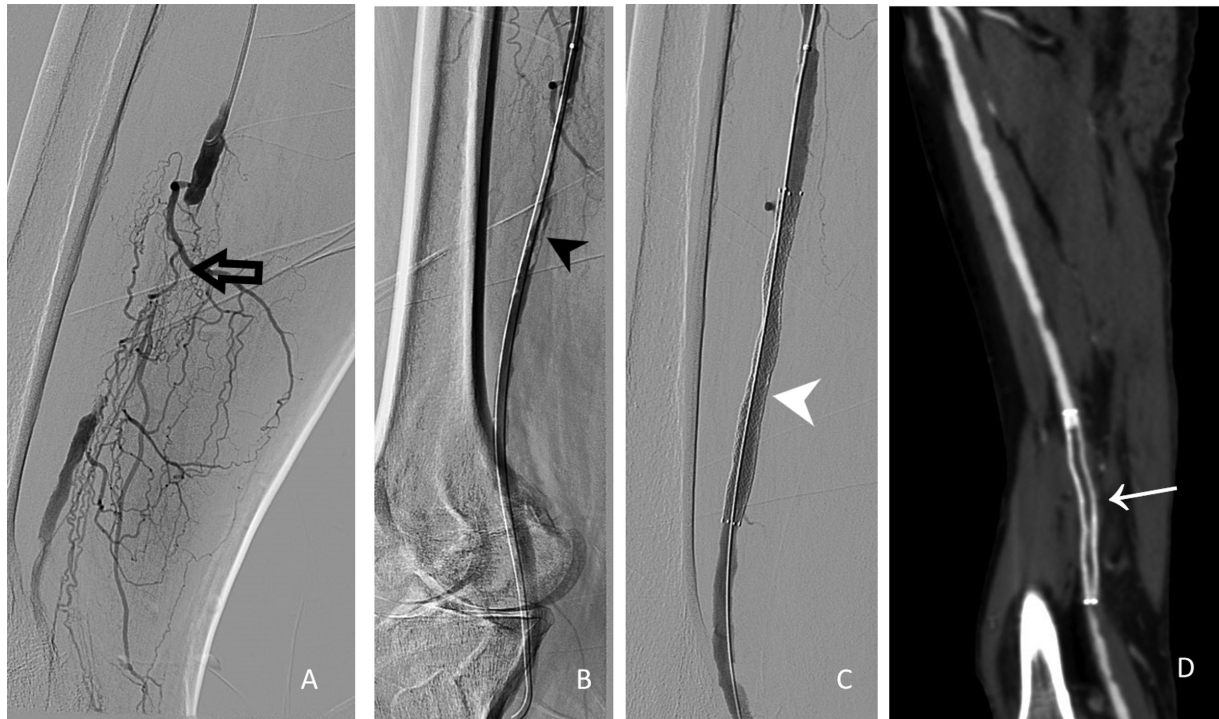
(A) Acute stent thrombosis of right superficial femoral artery. After crossing the lesion subintima balloon angioplasty was done which showed dissections and thrombus in the lumen (arrowhead in B) and hence underwent stenting which showed good flow in the stent (arrowhead in C). He presented after 2 days with increased pain in the calf. Computed tomography angiogram showed acute in-stent thrombosis (white arrow in D) which was lysed by catheter-directed thrombolysis.
